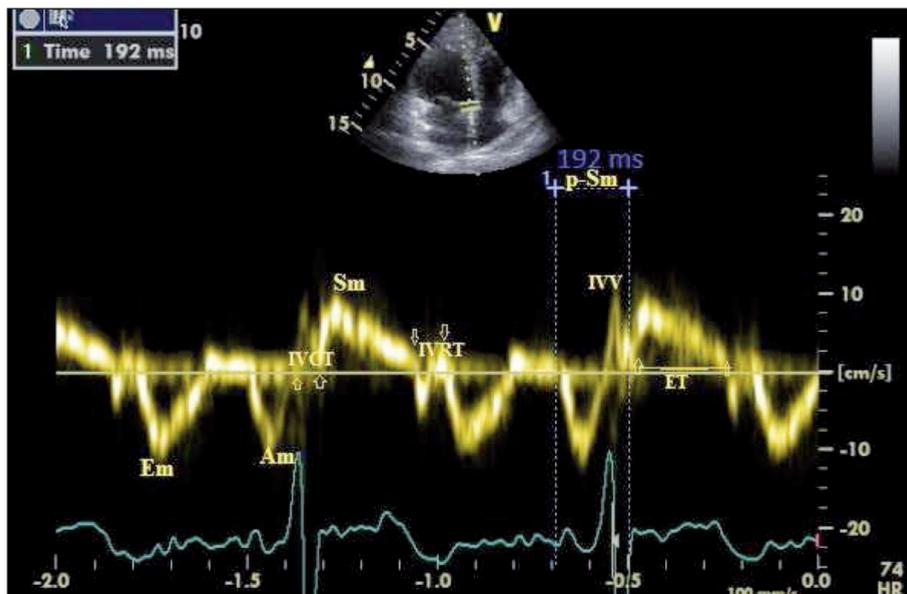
The parameters which we evaluate in tissue Doppler images (TDI) are shown.
